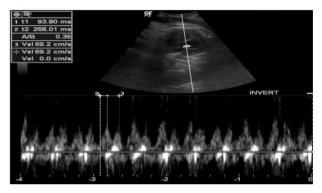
Measurements of the MPA AT, ET and AT/ET ratio using pulsed wave Doppler.
